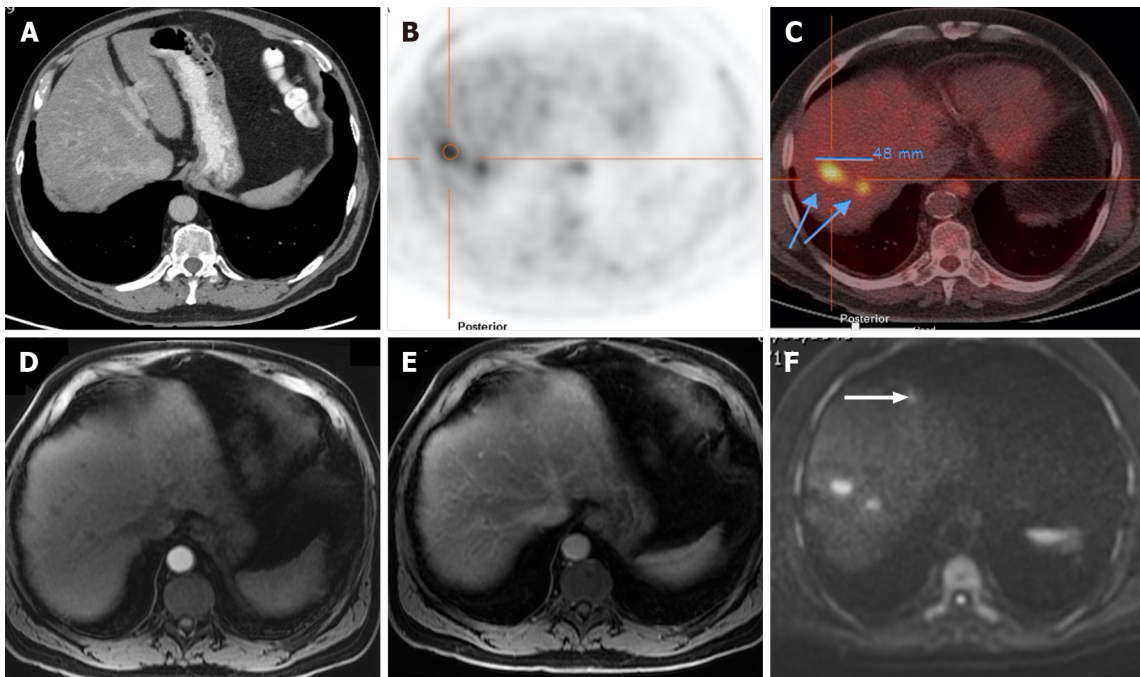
A 71-year-old man with colorectal carcinoma presenting with liver metastases. A: Axial contrast-enhanced computed tomography (CE-CT) in the portal-venous phase shows barely identified non-specific liver micronodules; B and C: Fluorodeoxyglucose positron emission tomography (PET)-CT shows two hypermetabolic lesions in the right lobe, consistent with viable neoplastic tissue; D: Axial fat saturated (FS) CE-magnetic resonance imaging (MRI) T1-weighted imaging (WI) in the arterial phase shows hypovascular liver lesions; E: Axial FS CE-MRI T1-WI in the venous phase confirms the liver metastases, showing hypointense nodules with venous ring enhancement; F: In the diffusion-weighted imaging study, these lesions are more conspicuous. Also, an additional metastasis (arrow) that was not detected either by CE-CT, CE-MRI, or PET-CT is shown.
